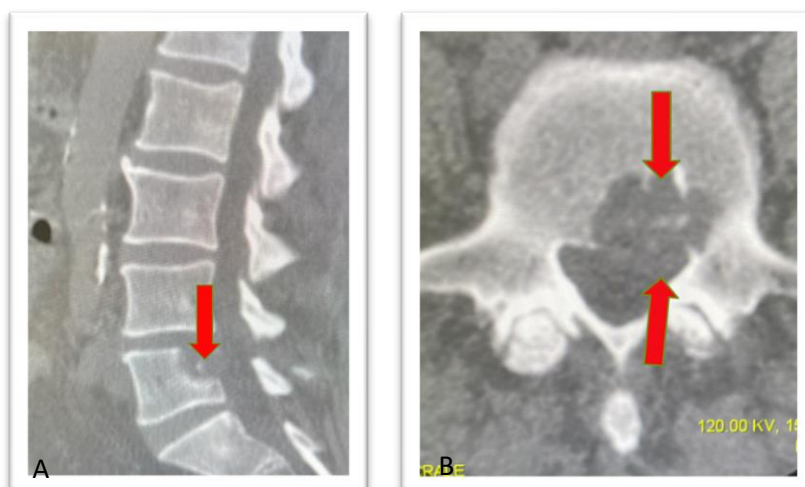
CT investigation with algorithms for bone: A: sagittal reconstructions; B: axial scan: osteolytic area with interruption of the posterior wall affecting the left hemibody of L5 (arrows).
